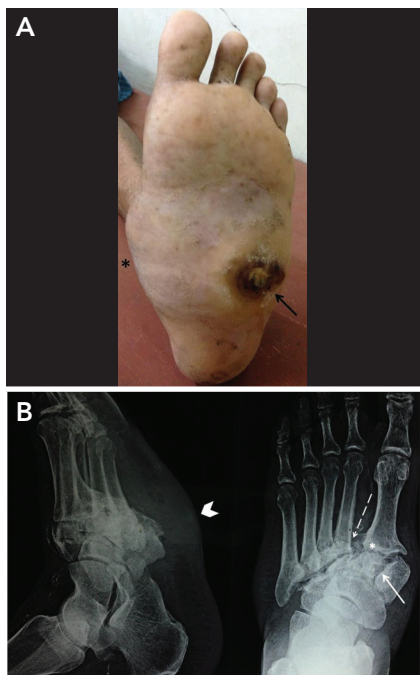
Case 2. *A*) Rocker-bottom deformity of the left foot (*) with midfoot plantar ulcer (arrow). *B*) X-ray showing fracture of the medial cuneiform (right side, solid arrow), lateral displacement of the second metatarsal base (right side, dashed arrow), and destruction of the tarso-metatarsal joints (*), suggestive of pattern II CF. The arrowhead (left side) denotes rocker-bottom deformity of the foot.
